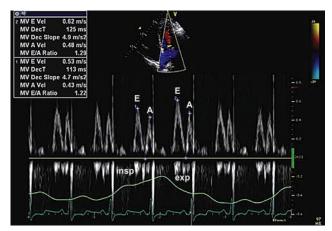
CP: apical four-chamber view with pulsed Doppler of mitral inflow in a patient with CP. The mitral E and A waves are labeled. The first beat of inspiration is recorded, and peak expiration beat is recorded and can be used to determine respiratory variation from expiration using the formula (expiration — inspiration)/expiration. At least three beats should be averaged. Significant respiratory variation is considered to be present when there is an inspiratory decrease of mitral inflow is >25%. However, maneuvers (preload reduction as in sitting up or increase in volume loading) may be required to demonstrate variation.
